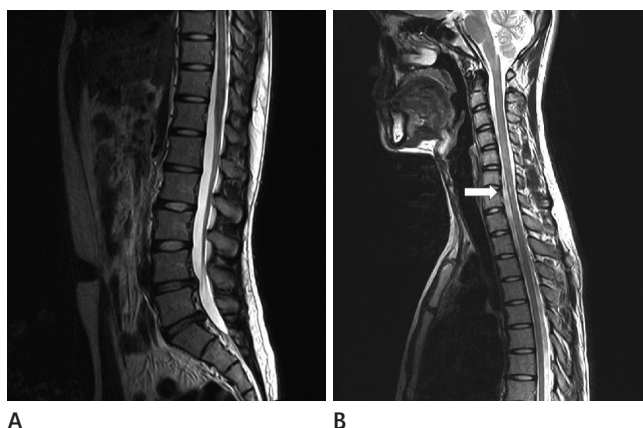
The whole sagittal magnetic resonance images of a 20-year-old male with back pain. There is multiple degenerative disc protrusion observed in the lumbar region (A), and the syringomyelia (arrow) is observed at the level of C6 in the whole spine sagittal MR images (B).
